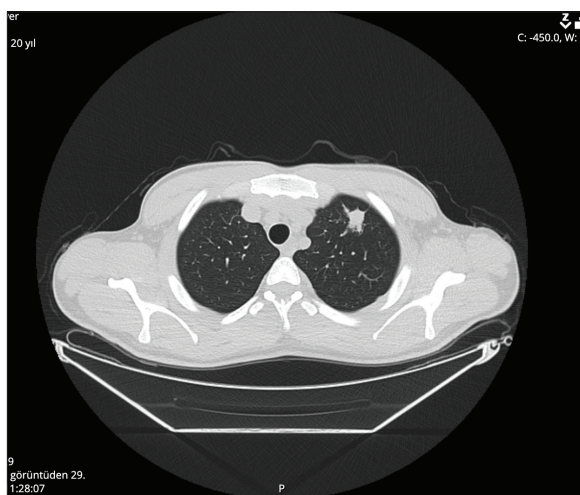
Thorax CT shows areas of minimal ground-glass opacity and reticular density increases about three nodular consolidated lesions with spiculated contours and fibrotic extensions to the pleura, the largest of which is 124 x 14 mm in size in the subpleural area in the anterior subpleural area in the apical-posterior segment of the left lung upper lobe.
